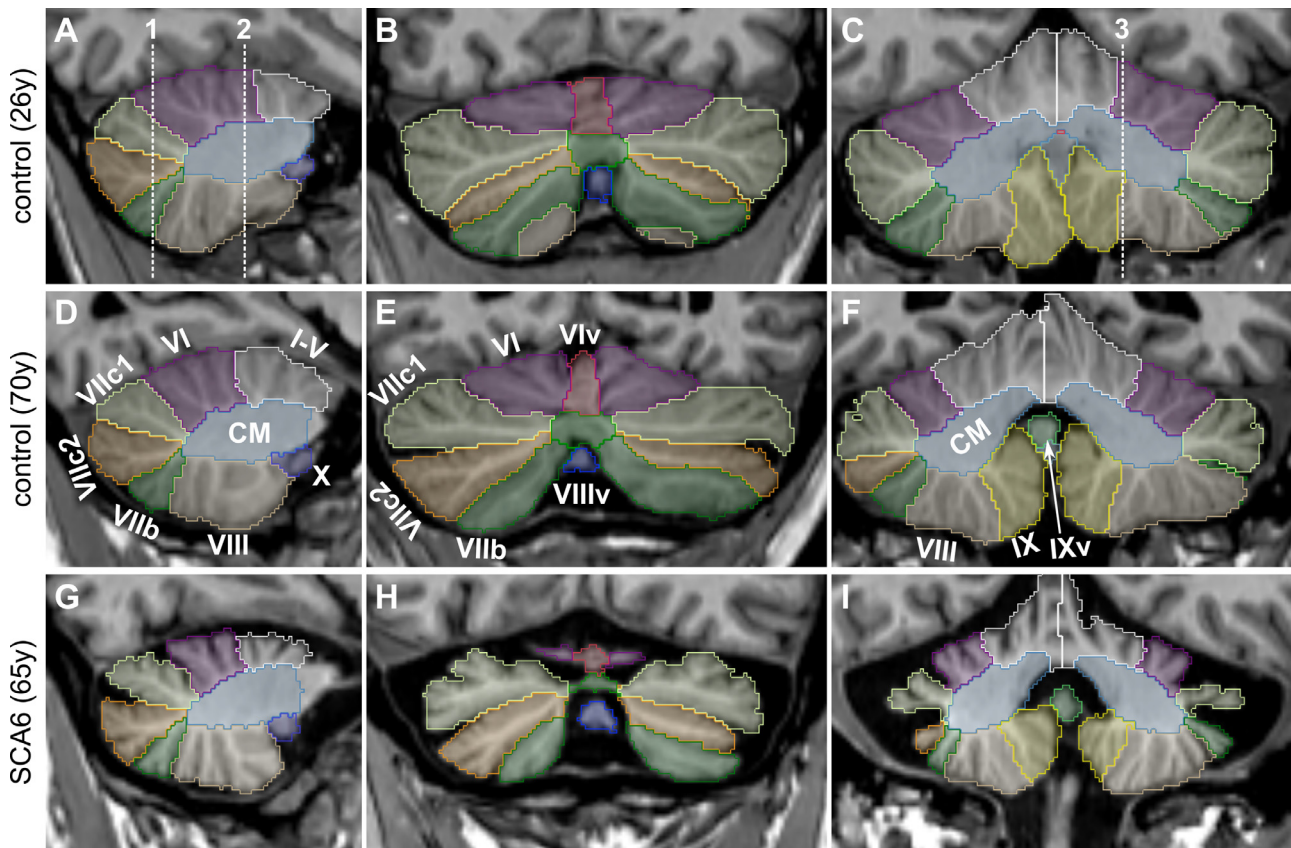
T1-weighted images of the cerebellum with superimpositions of the cerebellar lobules in a young healthy control (male, 26y, TIV = 1685 cm³), an elderly control (male, 70y, TIV = 1752 cm³) and an SCA6 patient (male, 65y, TIV = 1742 cm³) are presented from top to bottom row, respectively, indicating accurate segmentation across age. The left column shows the sagittal view of the cutting plane indicated by dashed line 3 in (C). The middle and right columns display coronal slices at the locations indicated by dashed line 1 and 2 in (A), respectively. The cerebellum of the SCA6 patient (G-I) exhibits considerable atrophy compared to the elderly control (D-F). The color scheme of the cerebellar segmentation is indicated in the middle row: I-V – lobules I to V, VI – lobule VI, VIv – vermis lobule VI, VIIc1 – Crus I, VIIc2 – Crus II, VIIb – lobule VIIb, VIII – lobule VIII, VIIIv – vermis lobule VIII, IX – lobule IX, IXv – vermis lobule IX, X – lobule X and CM – corpus medullare.
